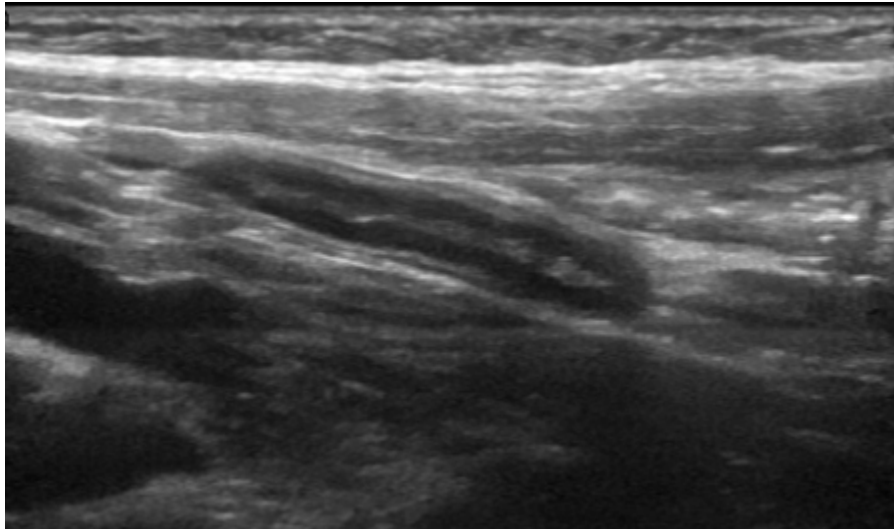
Image courtesy of: Ultrasoundpaedia Pty Limited: Ultrasound of the appendix - normal. <https://www.ultrasoundpaedia.com/normal-appendix/>. Published 2018. Accessed September 4, 2018.
